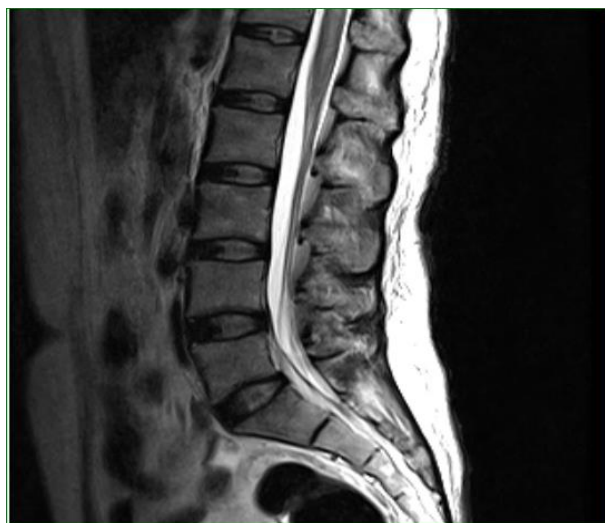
MRI image of lumbar spine tuberculosis myelitis
